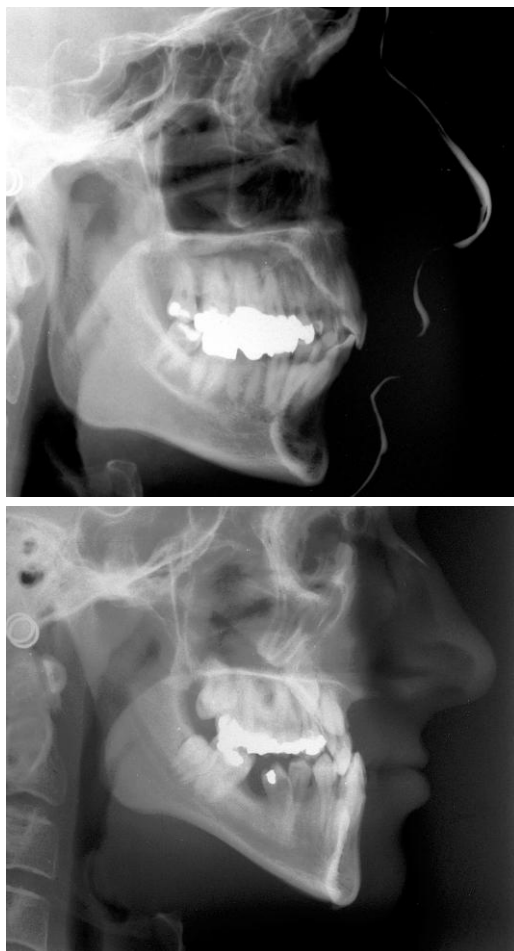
Image of the soft tissues on cephalometric X-rays using radiopaque cream (top) and soft tissue filter (bottom).
